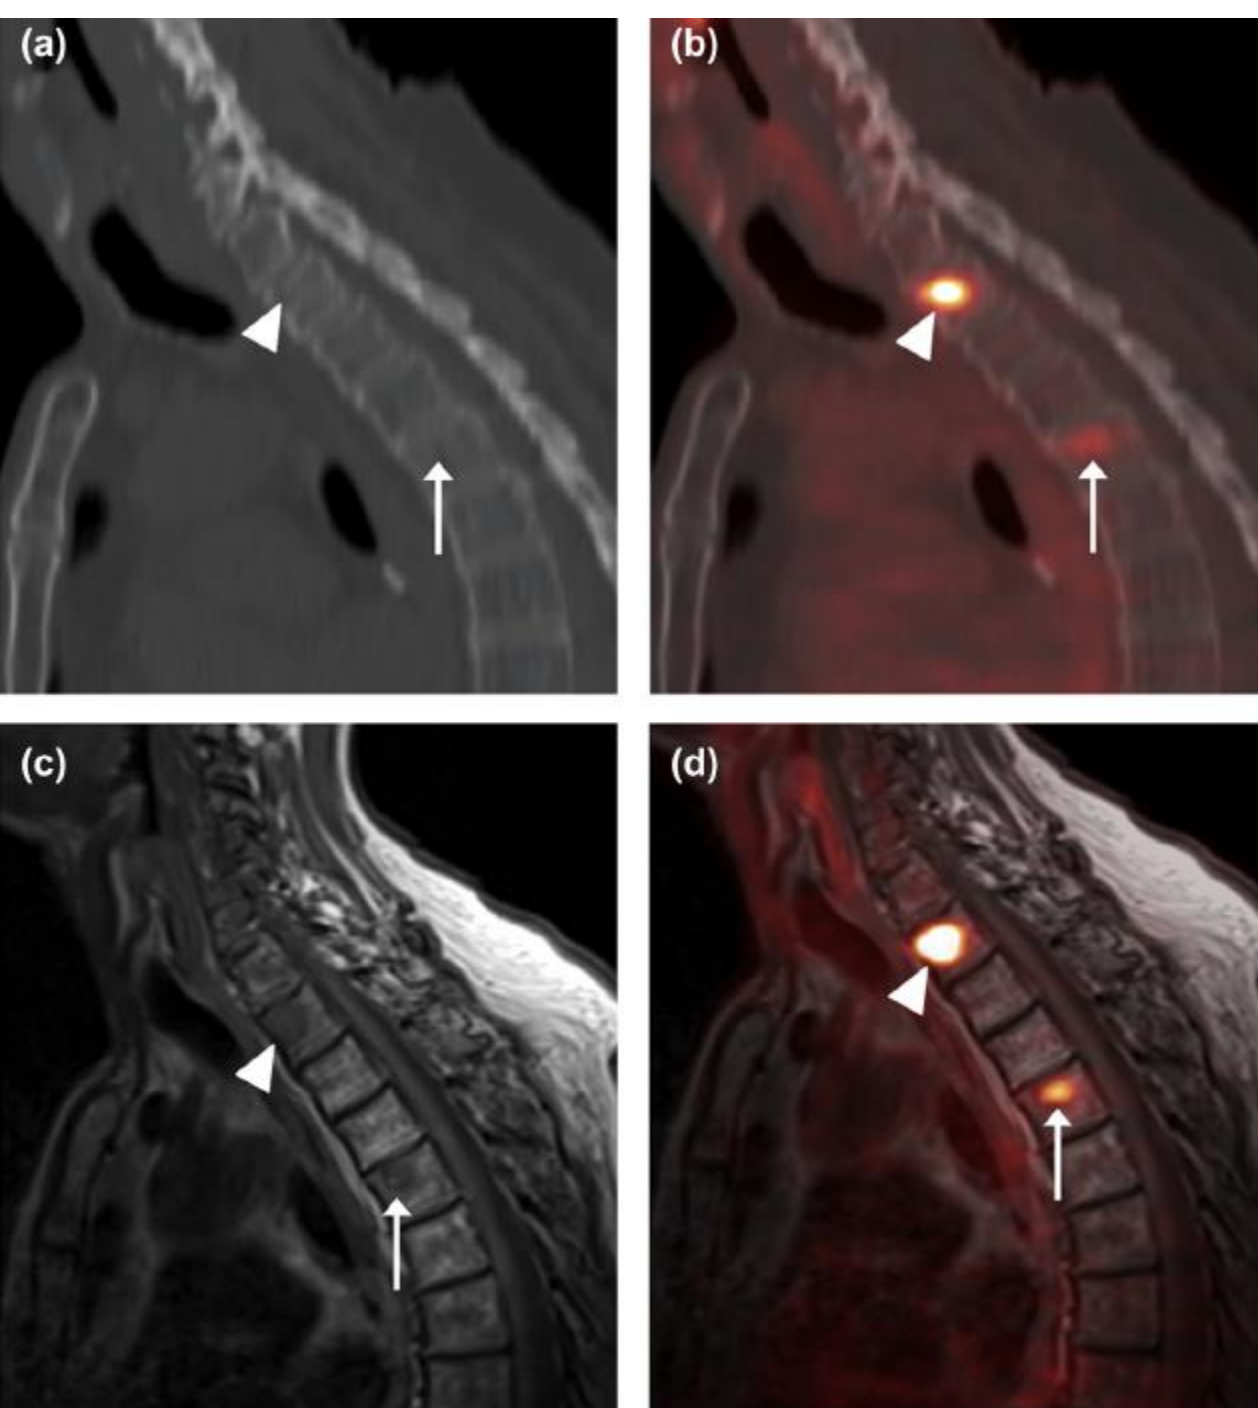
69-year-old man with known metastatic papillary thyroid carcinoma presented for restaging. Sagittal computed tomography (CT) images (a) revealed a subtle lytic lesion within the T2 vertebral body (*arrow head*) but a normal appearance of the T5 vertebral body (*arrow*). Sagittal CT images with 2-deoxy-2- ^{18}F fluoro-D-glucose-positron emission tomography (FDG-PET) fusion (b) demonstrated an FDG-avid focus in the T2 (*arrowhead*) vertebral body highly suspicious for metastatic disease. In contrast, a focus of more subtly increased FDG uptake in the T5 vertebral body (*arrow*) without a CT correlate was felt to be indeterminate, as both metastatic disease and degenerative disease could conceivably produce this appearance. Sagittal T1-weighted images (T1WIs) (c) from subsequent PET/magnetic resonance imaging (MRI) showed clear evidence of marrow replacement in the T2 (*arrow-head*) and T5 (*arrow*) vertebral bodies. Corresponding foci of FDG avidity on sagittal T1WIs with FDG-PET fusion (d) strongly supported the presence of metastases at both sites. These images show an example of the improved anatomic delineation of malignant osseous disease with PET/MRI relative to PET/CT, as well as the power of PET/MRI to distinguish osseous malignancy from degenerative remodeling.
